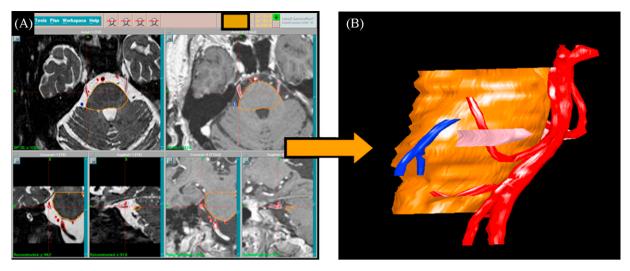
(A) Multiplanar (axial, coronal and sagital) dynamic display of the MRI (T2-SPIR and T1 enhanced). (A) Delimiting the structures of interest and (B) acquisition of a 3D model
